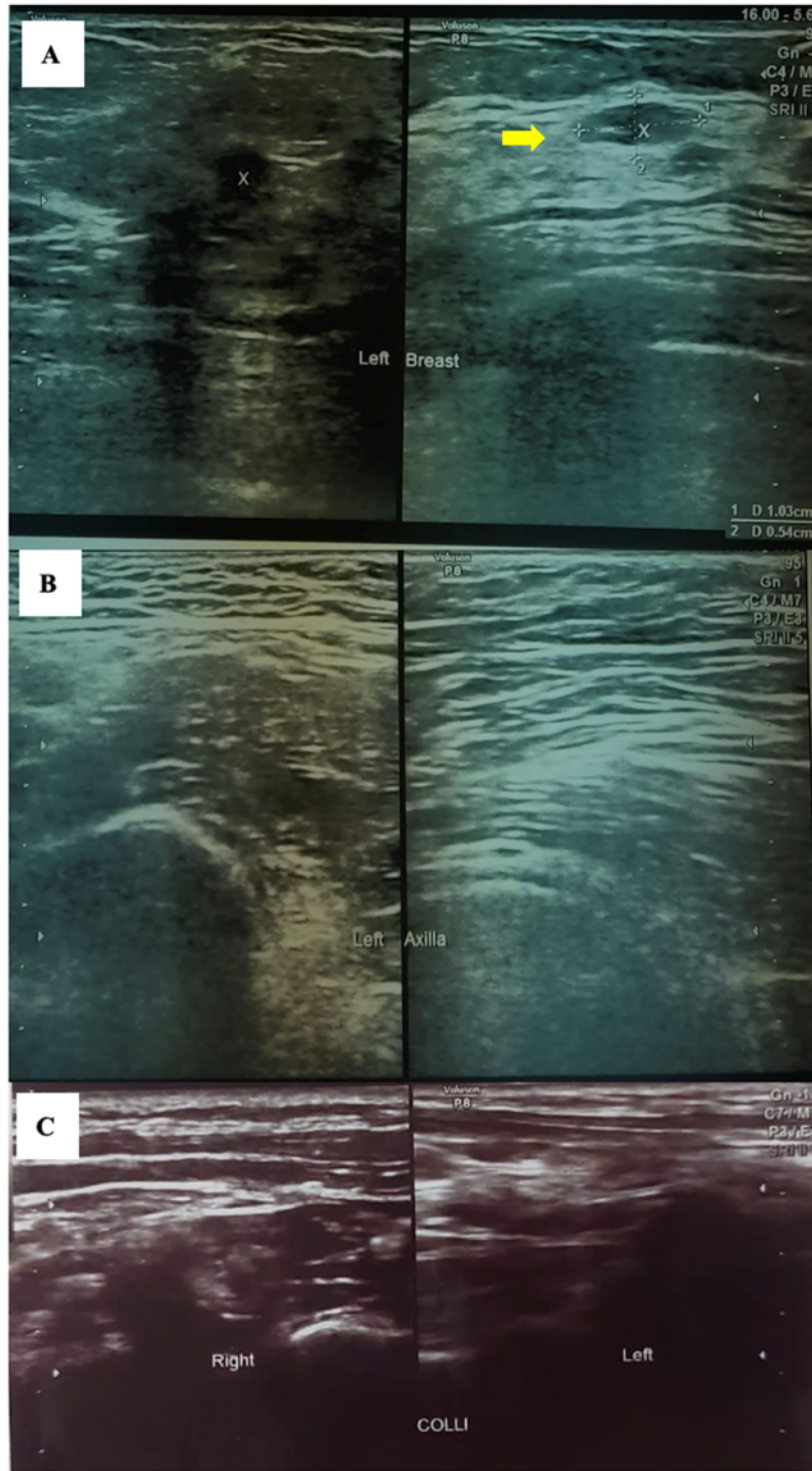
Ultrasonography after chemotherapy: (A) A regular hypoechoic mass 1.0 × 0.5 cm in the left breast (yellow arrow), (B) no enlarged lymph nodes in the left axilla, and (C) no enlarged lymph nodes in the neck. (For interpretation of the references to color in this figure legend, the reader is referred to the web version of this article.)
